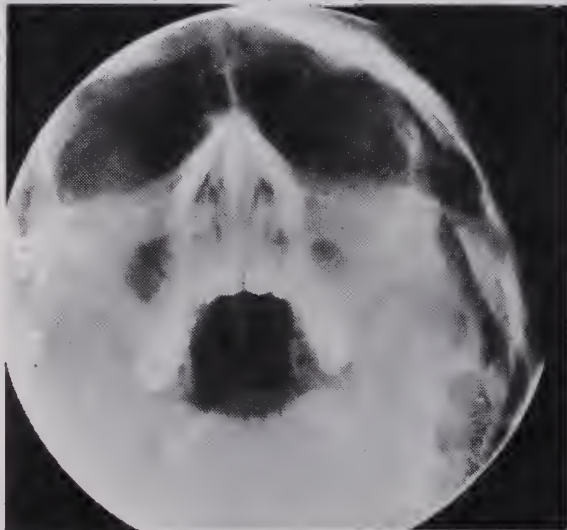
(A) — Sinus radiograph in a 48 year old female showing changes of maxillary sinusitis.
